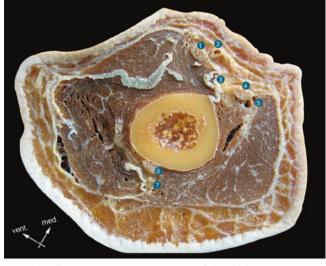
Section in <sup>1</sup>/<sub>4</sub> distal portion of the arm with materialisation of ultrasound beam for performance of a truncal block of the radial nerve
